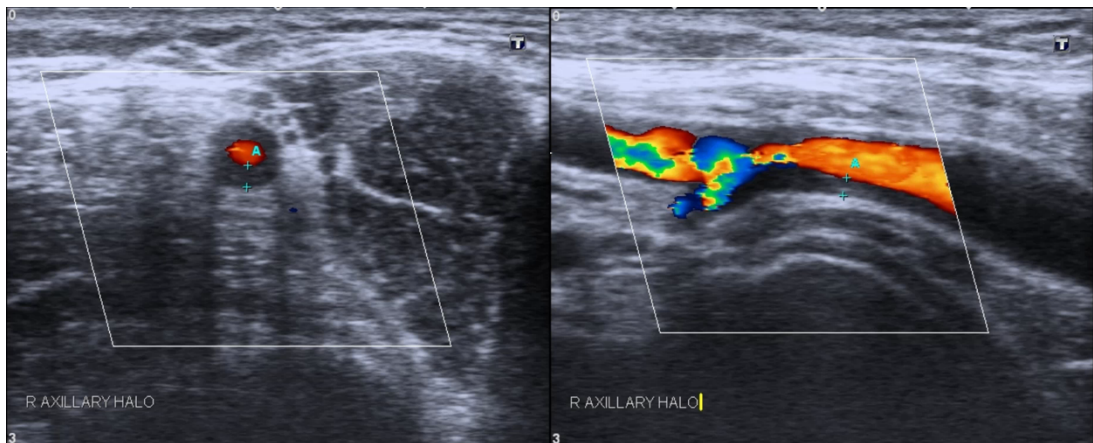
Transverse (left) and Longitudinal (right) views of the same axillary artery on colour doppler ultrasonography demonstrating halo sign and/or macaroni sign. Images acquired using 14 MHz linear probe on Toshiba Viamo ultrasonography machine.
